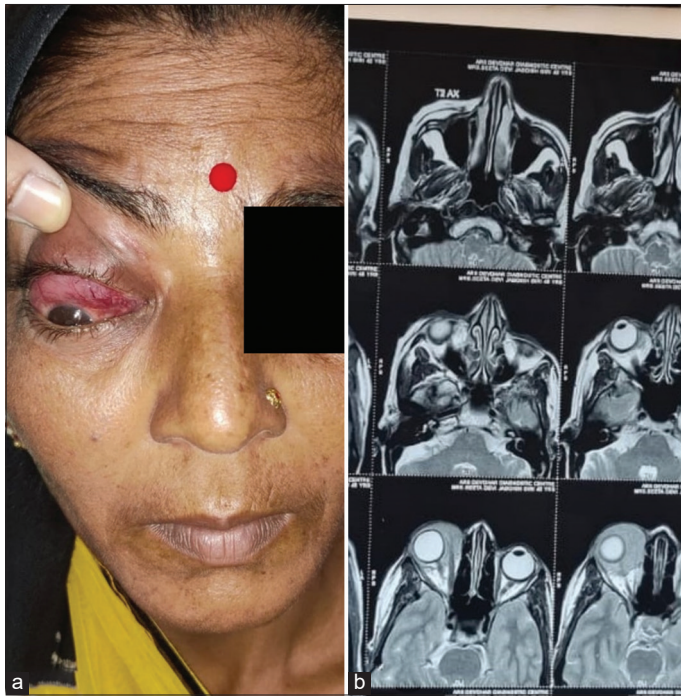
(a) Solid mass in subconjunctival fornix of the right eye and (b) magnetic resonance imaging shows post-contrast enhancement, lobulated extraconal mass medial aspect of the right orbit measures 35×30×18 mm
